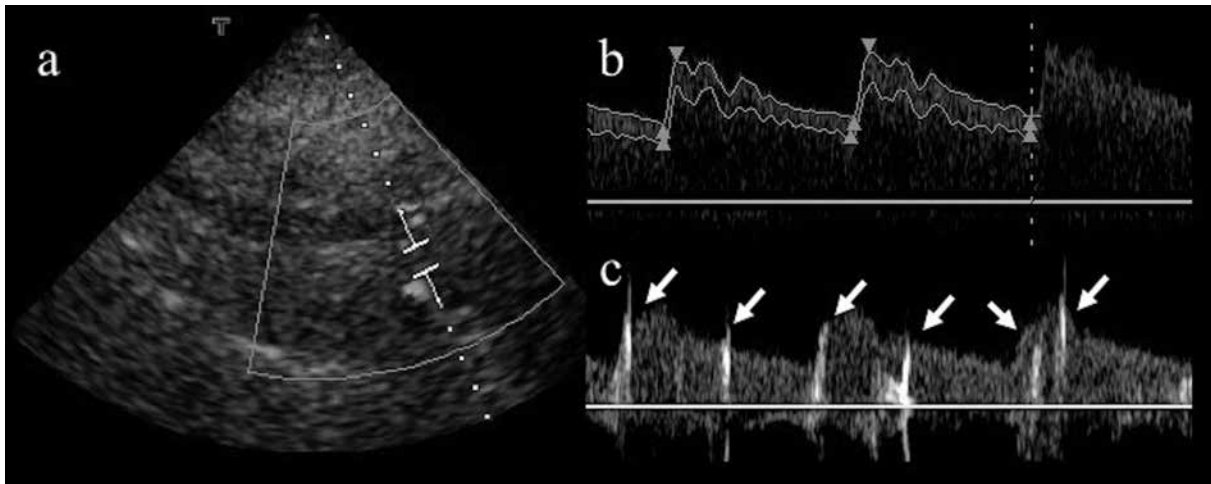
Right-to-left shunts diagnosis by Pulsed Doppler Ultrasound of internal carotid artery
